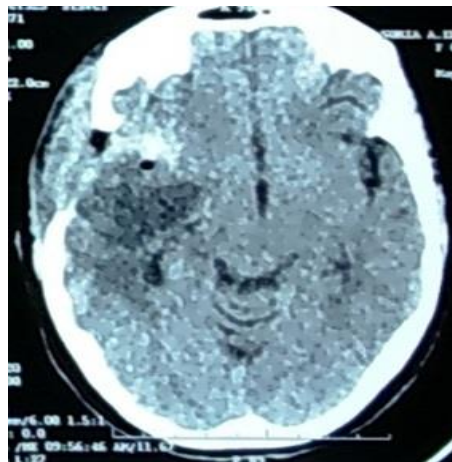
Showing CT brain axial cuts after tumor resection showing adequate gross total resection.
